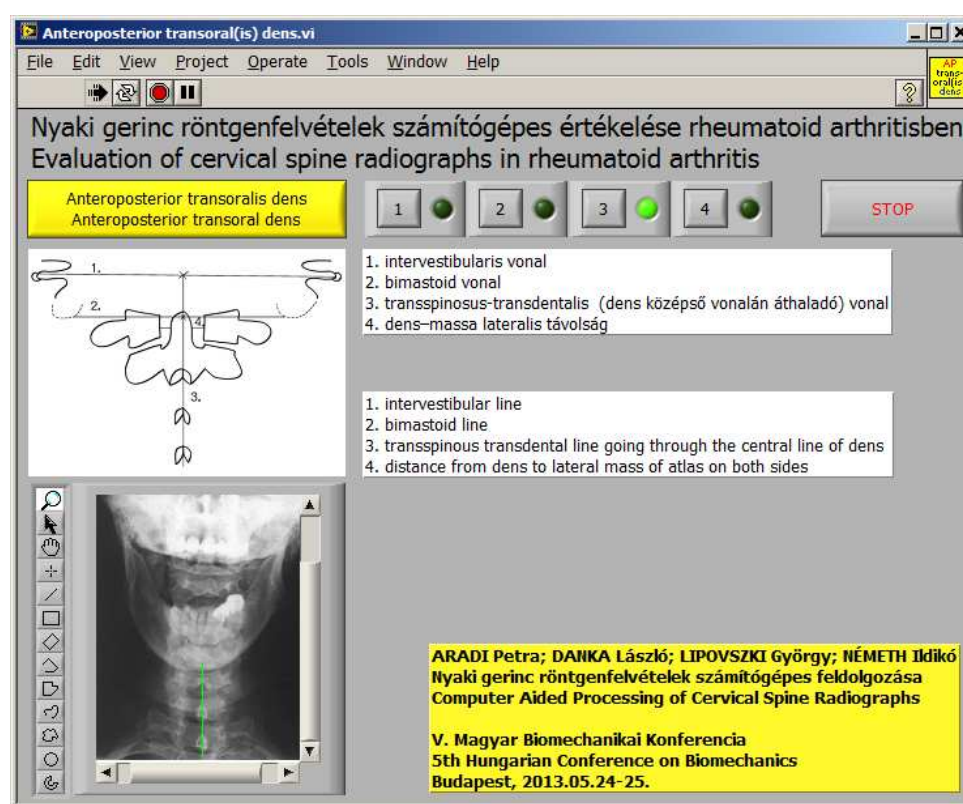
Drafting on anteroposterior transoral dens radiograph with step-by-step instructions
